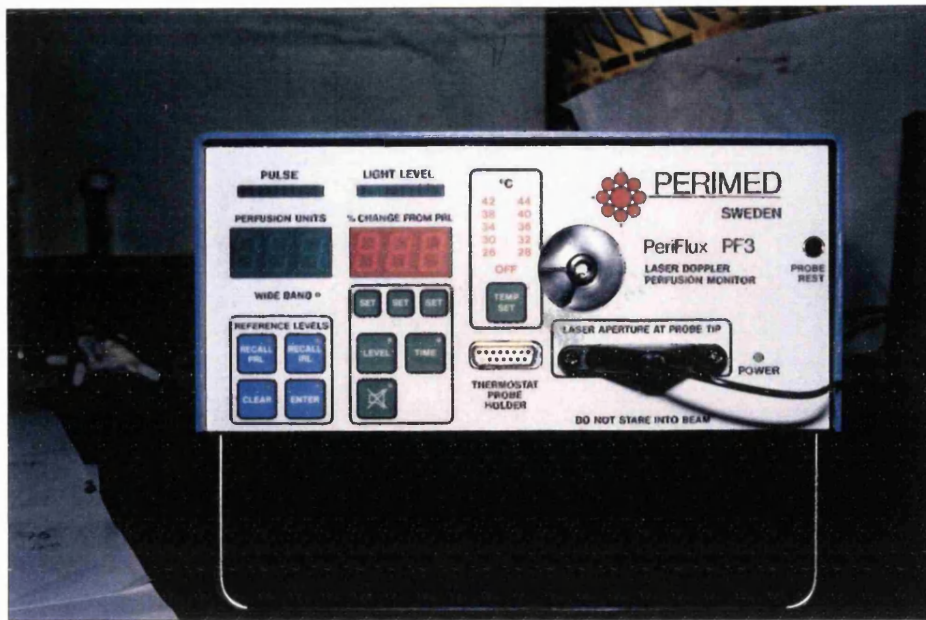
A perimed PF3 laser doppler flow meter.
